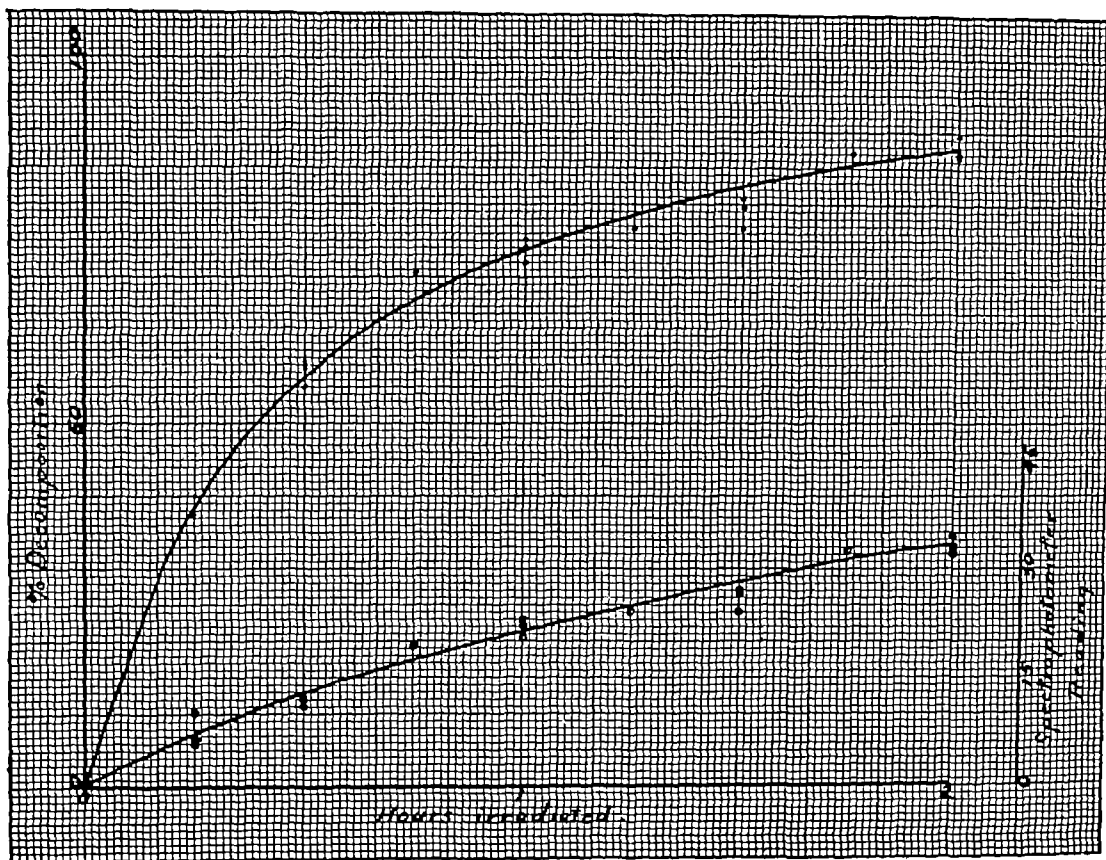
Relation between the length of exposure of the solution to x-rays in superlax and per centage change of methylene blue (marked by dots) The photometer reading is marked by circles
